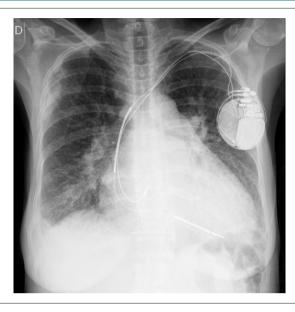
Chest X-ray (posterior-anterior view): presence of cardiac pacemaker, pulmonary congestion, and cardiomegaly (++++/4).
